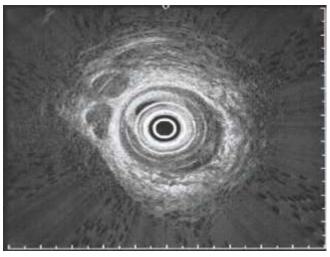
Endosonography demonstrating an 'advanced' local tumour. Note the breach of the outer white line that represents the interface between the oesophageal wall and the mediastinum.
